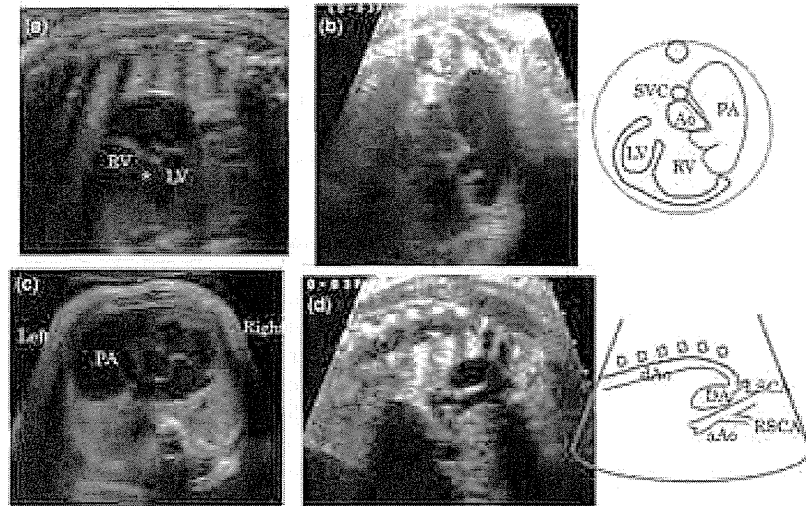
Foetal echocardiography shows a large ventricular septal defect (*) of the double-outlet right ventricle (a), aneurysmal pulmonary artery (b, c), and interruption of the aortic arch (d). aAo = ascending aorta; Ao = aorta; DA = ductus arteriosus; dAo = descending aorta; LV = left ventricle; LSCA = left subclavian artery; PA = pulmonary artery; RSCA = right subclavian artery; RV = right ventricle; SVC = supra caval vein.
